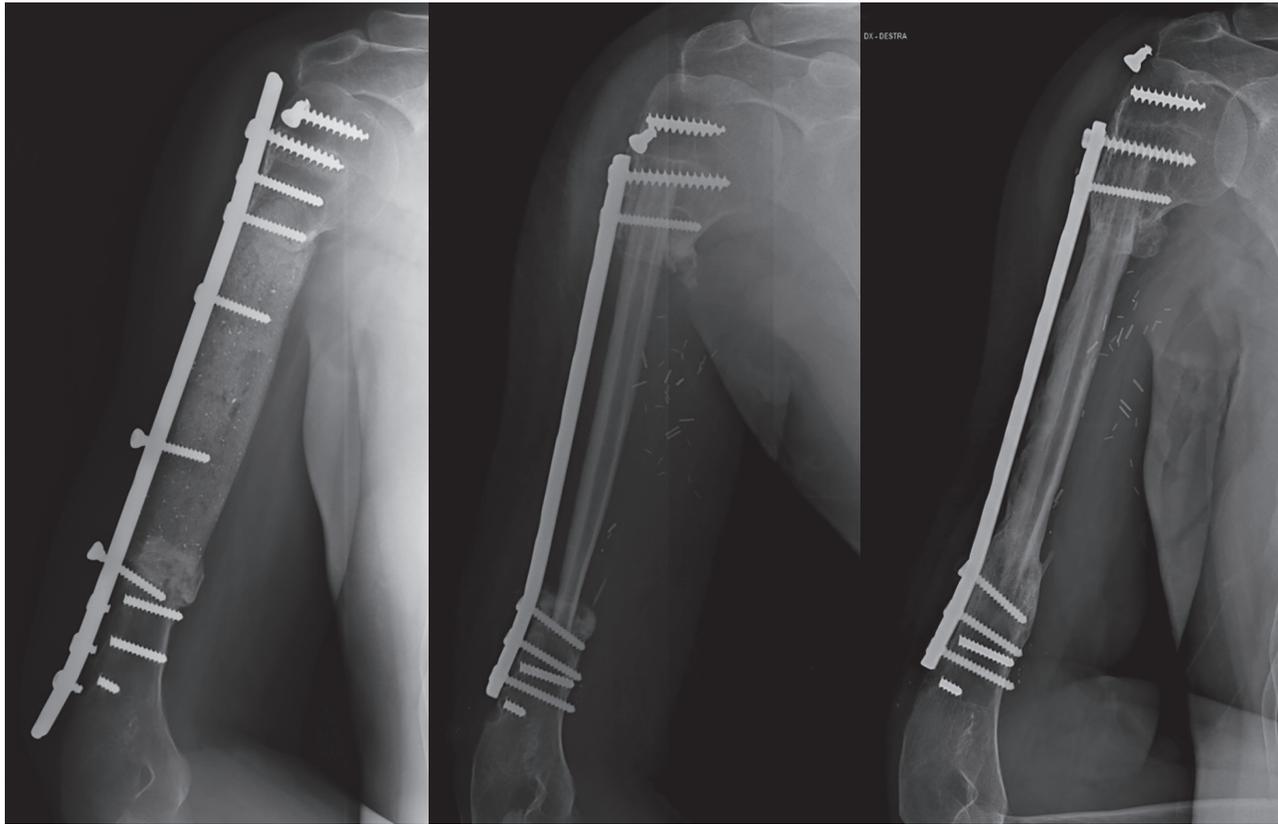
Case 16. A 44 year-old man reported Ewing sarcoma of the humeral diaphysis. He underwent neoadjuvant chemotherapy and intercalary resection. Reconstruction was performed with cement spacer and plate. Hardware breakage and plate loosening were the causes of failure. VFA was used as inlay graft. At last follow-up x-rays showed hypertrophy and excellent osteo-integration of the autograft.
